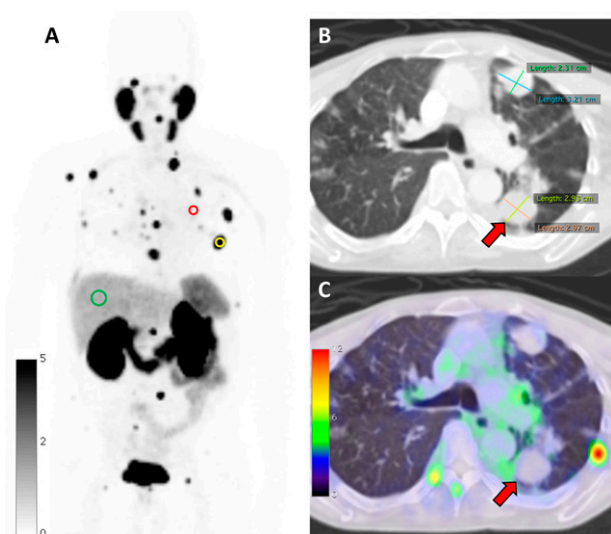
Patient Selection for PSMA-Based Radionuclide Therapy Using ^{68}Ga -PSMA-11 PET/CT
